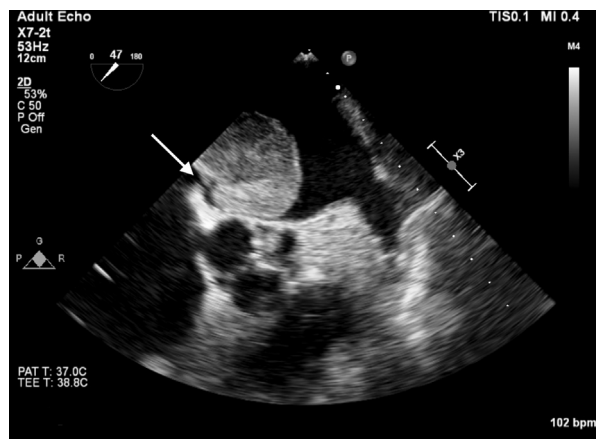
Modified midesophageal aortic valve short-axis transesophageal echocardiography view obtained during mid-diastole showing transient opening in the anterior atrial septum (white arrow) as a result of deformation by movement of the left atrial mass.
